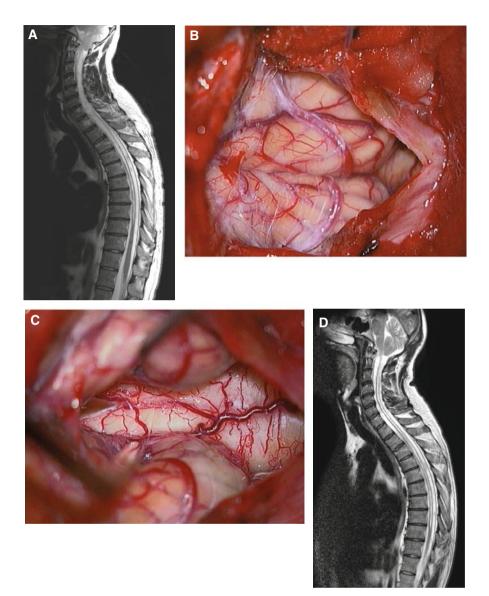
A This sagittal T2-weighted MRI shows a syrinx from C2 to Th9 in a 45-year old man with a Chiari I malformation and a 6-year history of sensory loss in his left arm and a slight gait ataxia. B This intraoperative view after dura and arachnoid opening demonstrates the cerebellar tonsils reaching into the spinal canal. C After bipolar coagulation at the tonsillar tips, the Foramen of Magendie is inspected and patent. No further manipulations were required and the dura was closed with a spacious graft. D This postoperative MRI after 9 months shows a free CSF passage at the foramen magnum and a decrease of the syrinx. Symptoms remained unchanged
